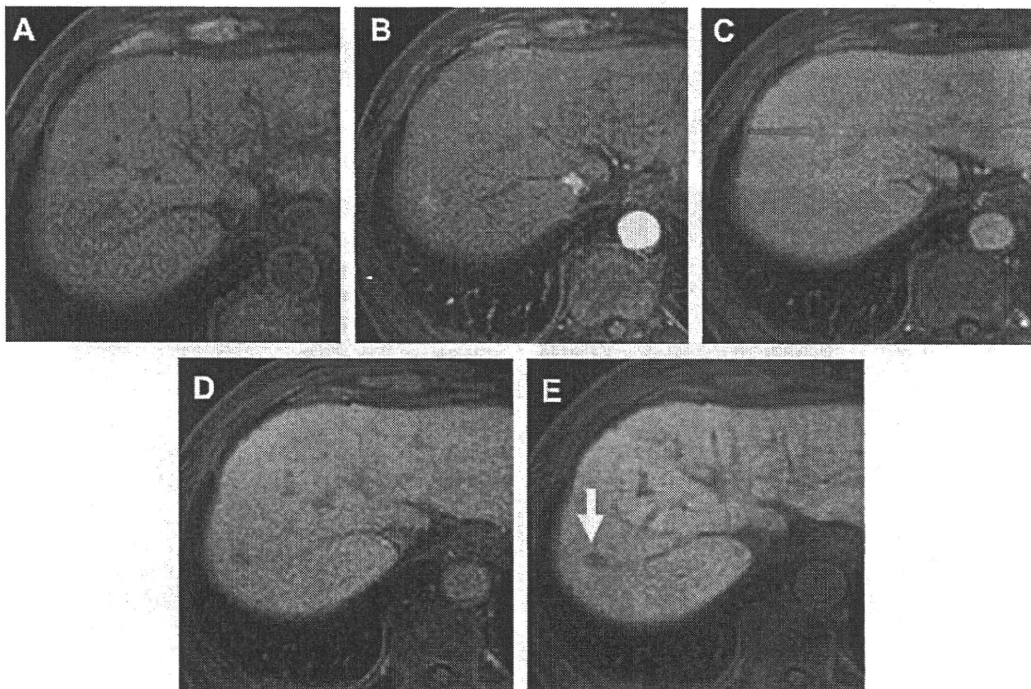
Dynamic enhancement patterns of well-differentiated HCC in axial 3D fat-saturated T1-weighted GRE images (TR/TE = 3.6/1.7 ms, flip angle = 15°), presenting before (A) and in the arterial phase (B), portal phase (C), equilibrium phase (D), and hepatocyte-selective phase (E) after intravenous injection of Gd-EOB-DTPA. Well-differentiated HCC is commonly observed as hypointense in the hepatocyte-selective phase (arrow).
